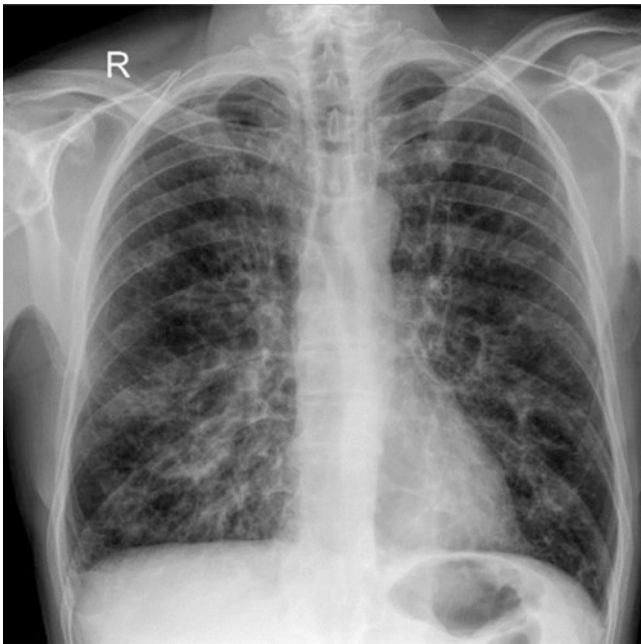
Anteroposterior chest X-ray showing bilateral lung opacities. (With permission from Ramos AL et al. *International Journal of Infectious Diseases*, 2022-02-01, Vol. 115, pp. 185–188 [3])
